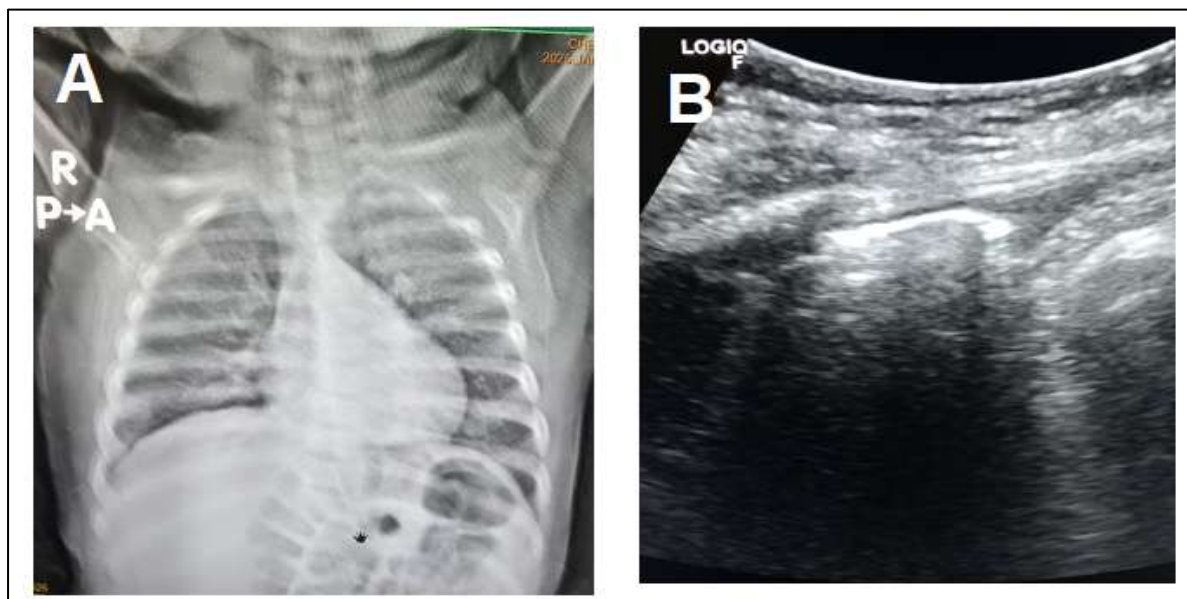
(A) Chest X ray PA view shows bilateral increase lung density with prominent bronchovascular marking, (B) Axial ultrasound scan of the chest shows longitudinal echogenic B lines obscuring the lung parenchyma denoting inflammatory interstitial changes.
